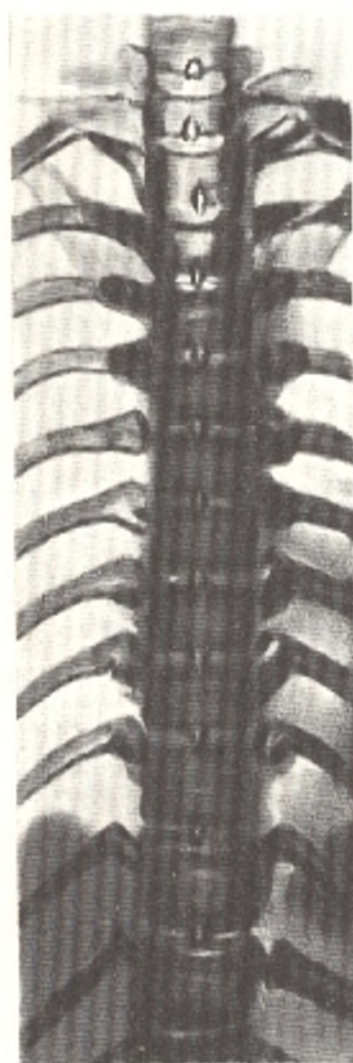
X-ray picture of the thoracic vertebral column of a 20-year-old male (anteroposterior view)
